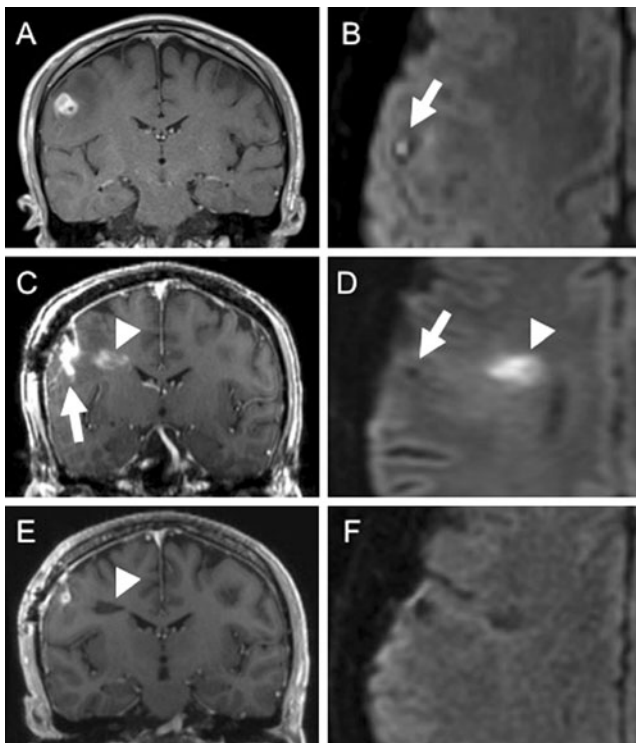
Sequential magnetic resonance imaging of the brain in a patient with *P. acnes* intraparenchymal abscess. a Coronal T1 MRI with gadolinium at initial presentation shows a 1.2-cm multilobulated rim-enhancing lesion in the right frontal lobe with surrounding edema. b Axial diffusion weighted imaging at the same time point as a shows reduced diffusivity (hyperintensity) within the center of the lesion (arrow). c Coronal T1 MRI with gadolinium following surgical resection of the mass shows post-surgical changes within the biopsy cavity (arrow) and a new rim-enhancing lesion medial to the biopsy site (arrowhead). d Axial diffusion weighted imaging at the same time point as c shows no reduced diffusivity within the biopsy cavity (arrow) and reduced diffusivity within the center of the new lesion (arrowhead). e Coronal T1 MRI with gadolinium following antibiotic therapy shows interval resolution of enhancement (arrowhead). f Axial diffusion weighted imaging at the same time point as e shows complete resolution of abnormal reduced diffusivity
